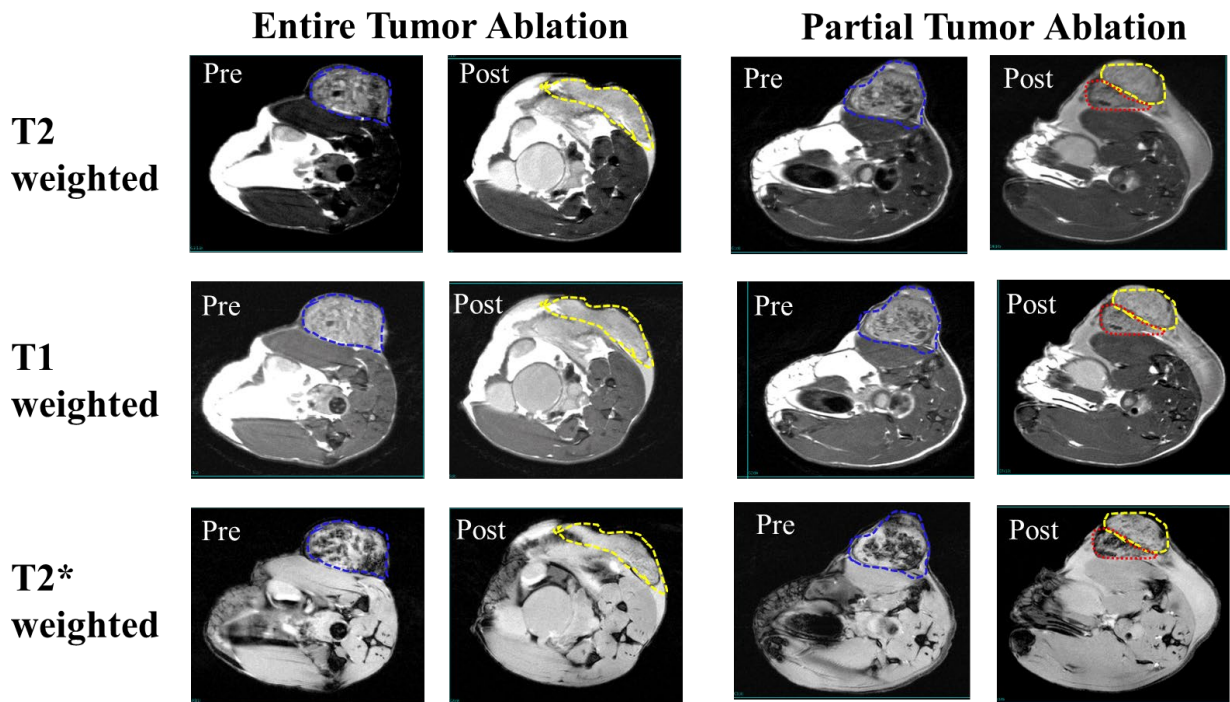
Characterization of MRI signal pre and post histotripsy. Pre- histotripsy tumors (blue dashed lines) have a heterogenous hyperintense appearance, with varying degrees of heterogeneity. Within one day post histotripsy, the ablated volume (yellow dashed lines) appears homogeneously hyperintense as compared to the heterogeneous mottled appearance of pre-treatment tumor on T2, T1 and T2 weighted images. In addition, the treated tumor changes configuration to conform to the shape of the body wall, as expected since the tumor becomes a fluid acellular homogenate with no capsule surrounding the treated cavity. In cases of partially targeted tumors, MR can distinguish between ablated (yellow dashed lines) and unablated tumor volume (red dashed lines), providing valuable early feedback on imaging differences between treated and untreated tumor.*
